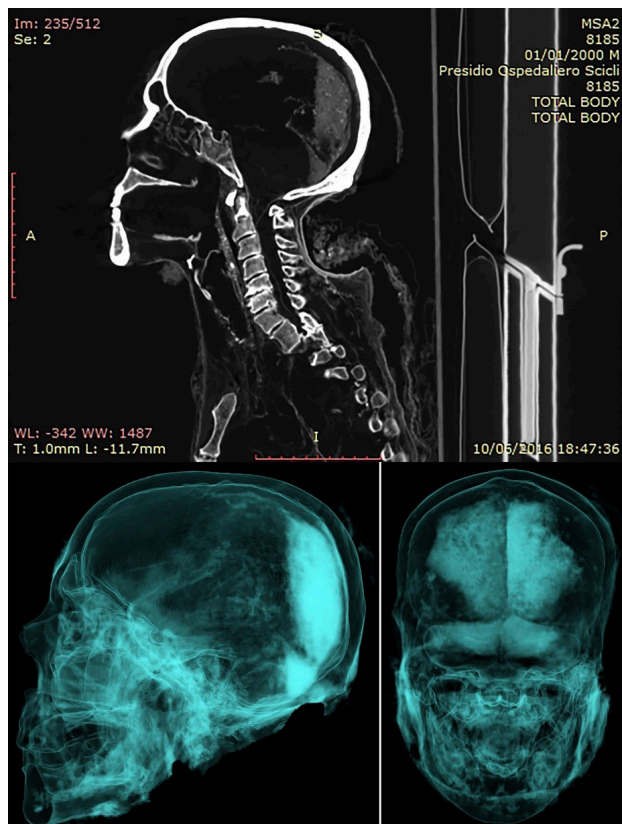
CT imaging of the head in sagittal (above) and 3D reconstructions (below). Encephalic remnants in the posterior cranial vault, with clearcut distinctions of hemispheres and cerebellum.
